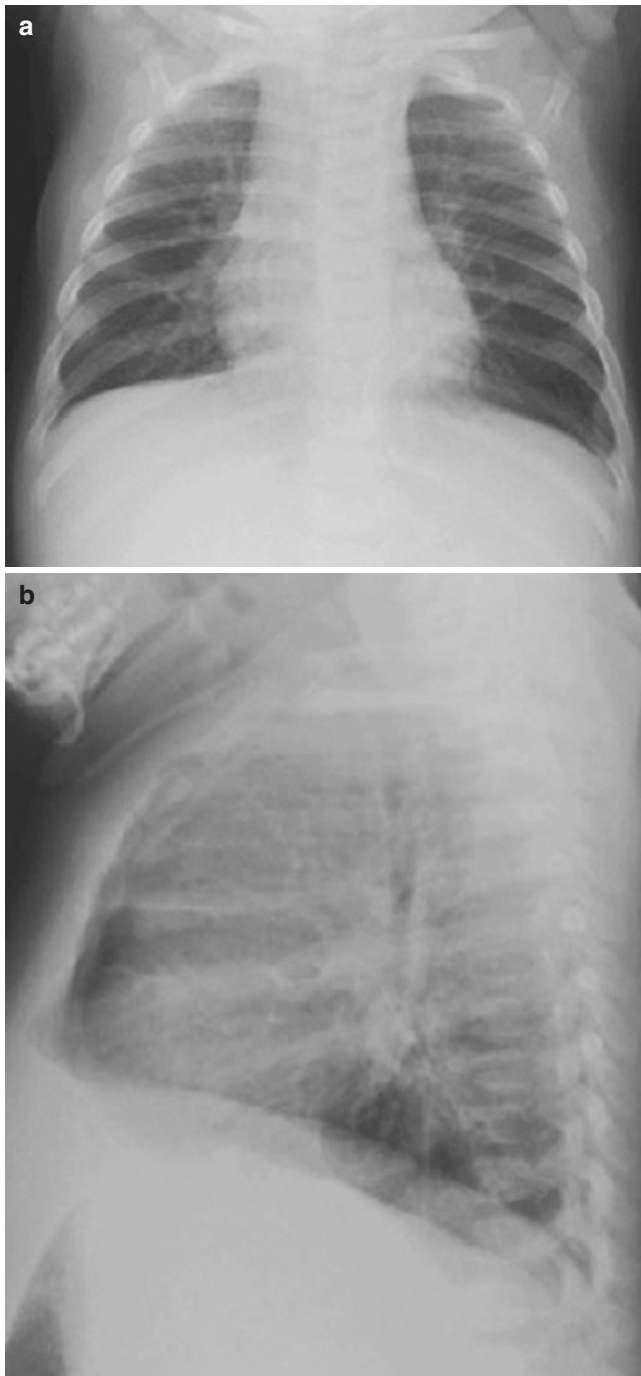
PA (a) and lateral (b) chest radiographs show diffuse bronchial wall thickening, multifocal subsegmental atelectasis, and hyperinflation. Hyperinflation must be present on all images to be abnormal. If lacking on one image, there is no air trapping. Bronchial wall thickening or peribronchial thickening (PBT) is a common manifestation of asthma and is indistinguishable from that seen in lower airway viral infections. However, PBT often will be recognizable in known asthmatics who are currently asymptomatic. This scenario is also the initial imaging manifestation in many children with cystic fibrosis. Hyperaeration is seen in asthmatics who are acutely symptomatic as is true for infants with bronchiolitis. Subsegmental atelectasis is often present in acutely ill asthmatics as well as infants with bronchiolitis
